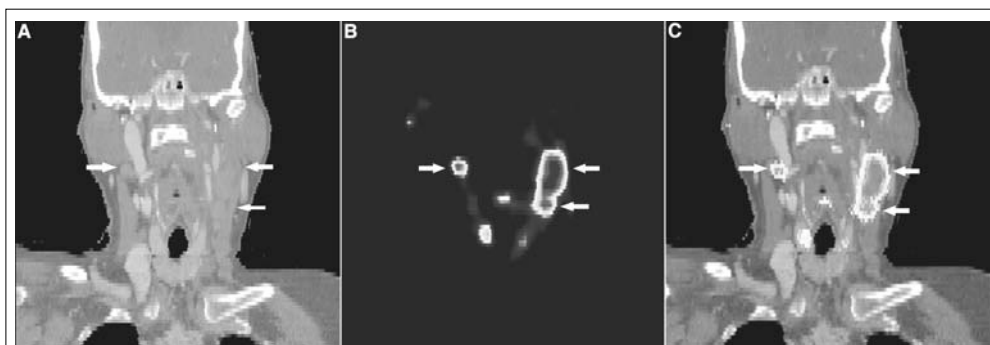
Fusion (C) of CT (A) and coronal immuno-PET (B) images with ^{89}Zr -cmAb U36 of a head and neck cancer patient with a tumor in the left tonsil and lymph node metastases (small arrows) at the left (level II and III) and right (level II) side of the neck. Images were obtained 72 hours p.i.. In these slices, only the lymph node metastases are visible.
